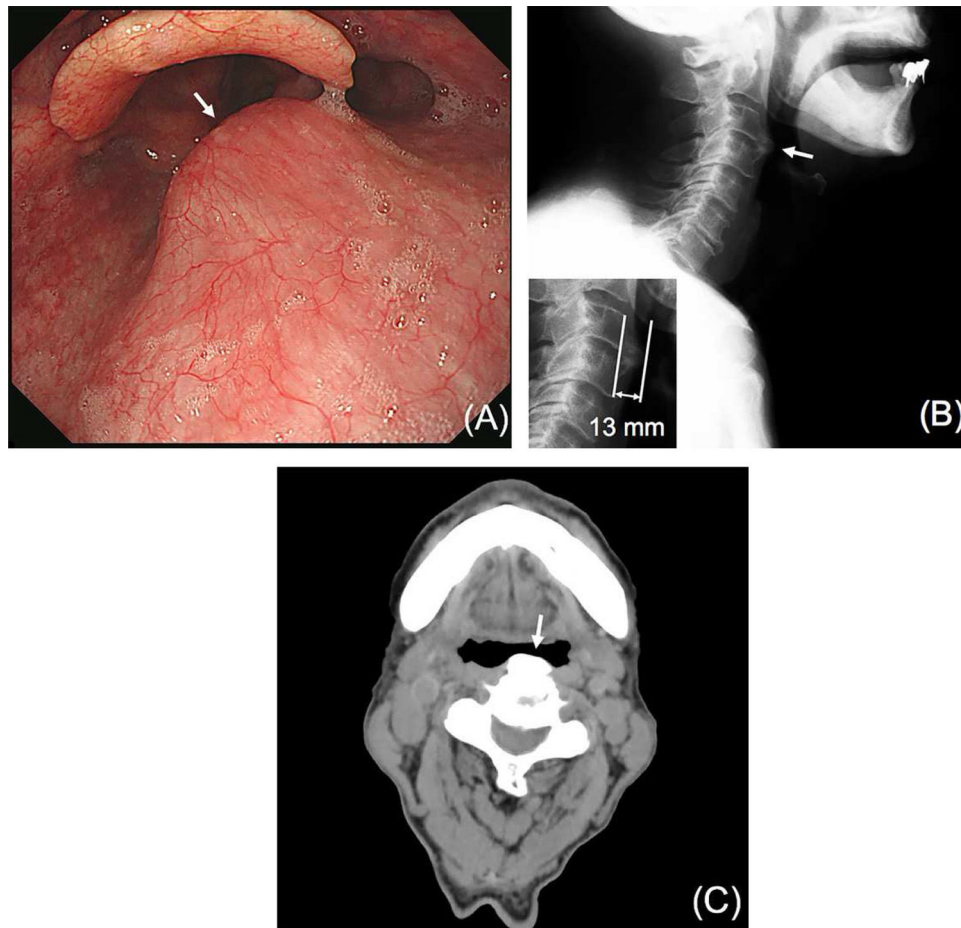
An extrinsic posterior hypo-pharyngeal mass covered by normal mucosa was found at presentation (A, arrow). Pharyngeal compression by ossification of the anterior longitudinal ligament at the level of C3–C4 on a lateral cervical spine radiograph (B, arrow) and at the level of C4 in the axial plane of a computed tomography scan image at presentation (C, arrow). The distance between the tip of the osteophyte and the anterior vertebral margin was 13 mm (B, lower left).
